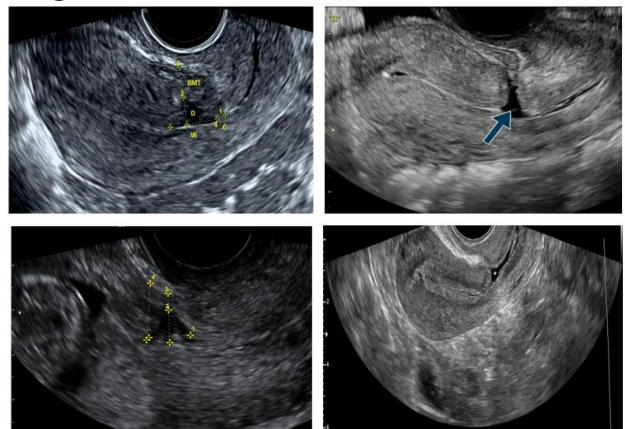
Shows ultrasound uterine niches.
